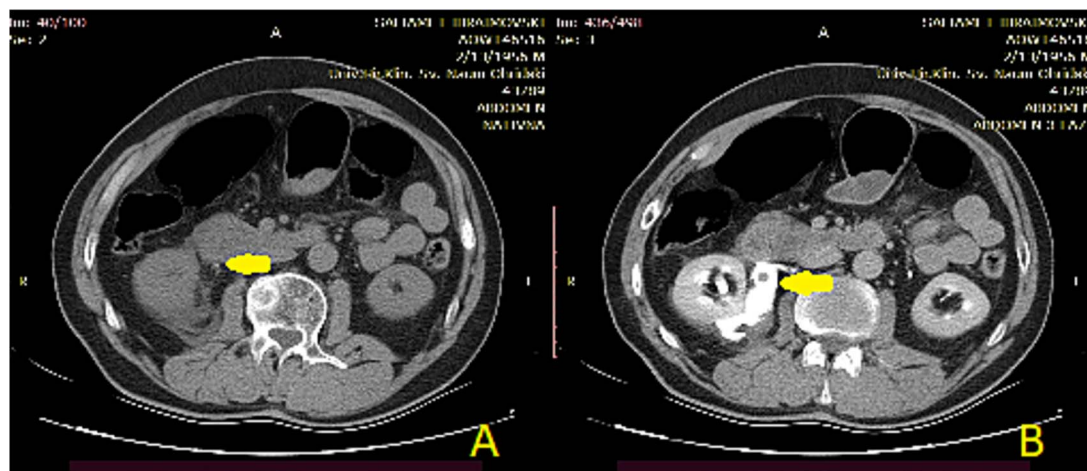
A. Abdominal axial CT, non-contrast series shows fluid content around the right kidney and 2 mm mineral structure in the right ureter (arrow) B. Prolonged phase of the contrast-enhanced CTU tract shows contrast extravasation around the right kidney with a filling defect at the level of proximal right ureter (arrow).
